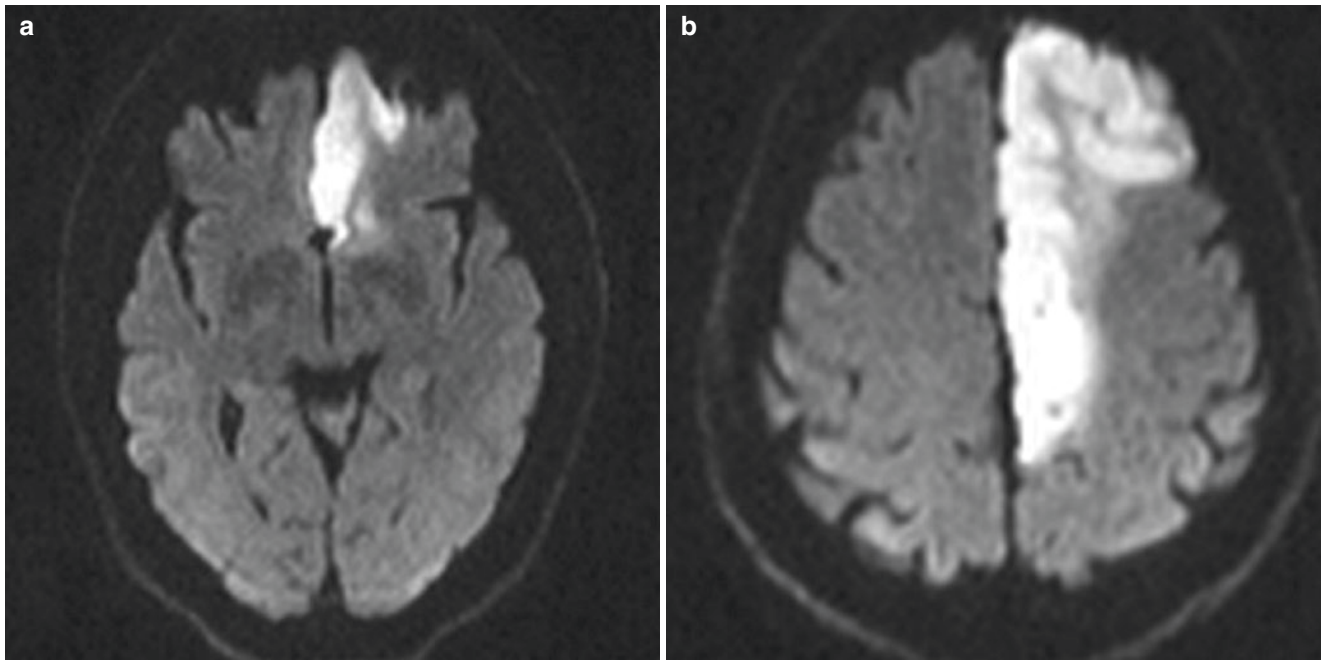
ACA infarction. DWI shows acute infarction of the left ACA territory including anterior medial surface of the frontal lobe (a), extending from the frontal pole to the parieto-occipital sulcus (b)
